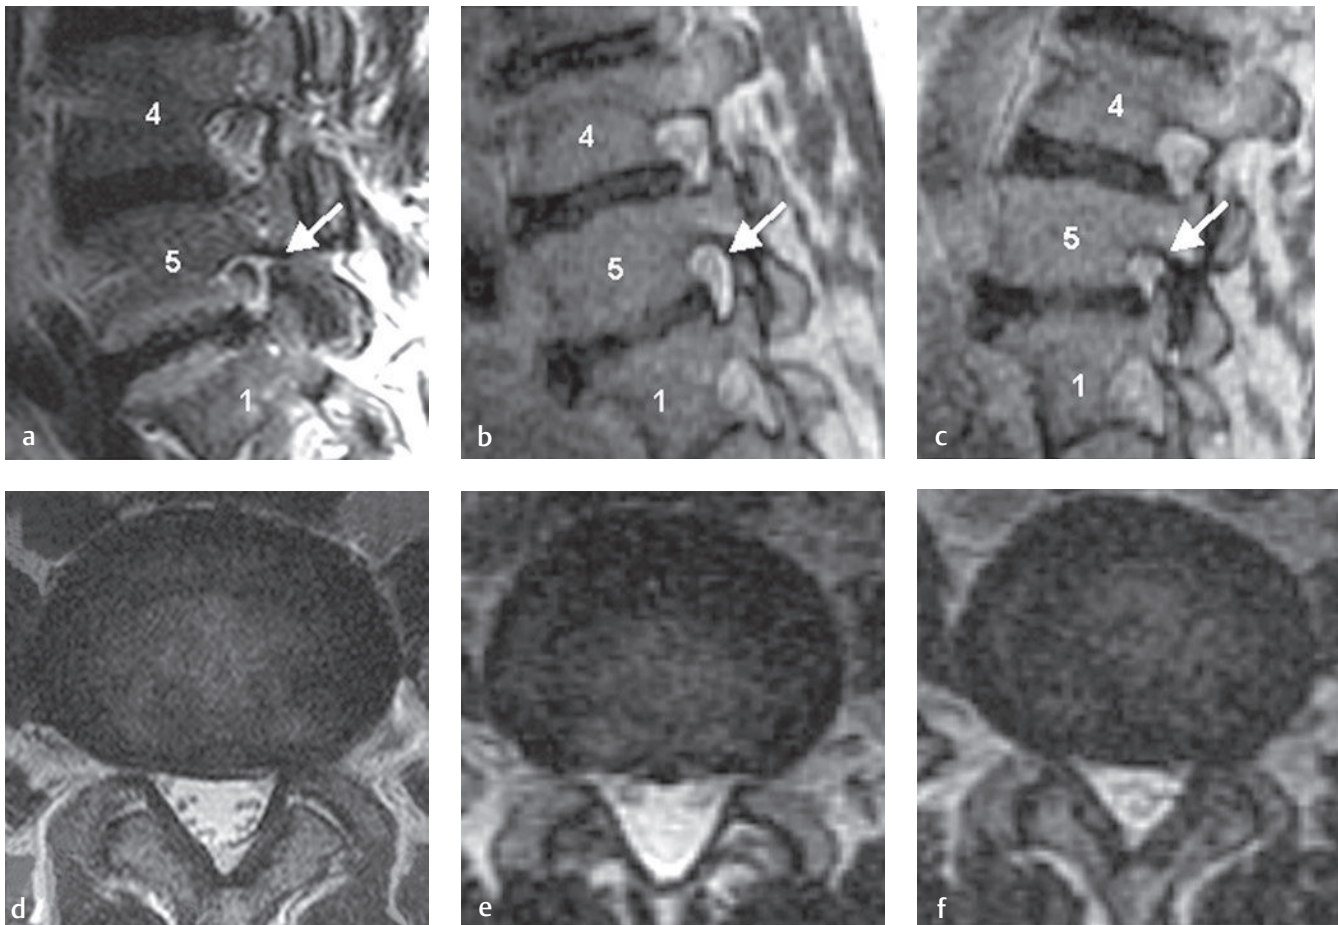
Load-bearing spine imaging: seated positional paradigm. These (a–c) sagittal and (d–f) axial T2-weighted images were obtained in a specially designed vertically open 0.5-T MRI scanner (General Electric Medical Systems). The patient was seated and images were acquired in (a, d) neutral, (b, e) flexion, and (c, f) extension positions. (a) The L5-S1 foramen shows a slight foraminal stenosis with deformity of the epidural fat (*arrow*) on the conventional image. (b) This image obtained with the patient in seated flexion shows improvement, with increased epidural fat surrounding the exiting nerve (*arrow*). (c) This image obtained with the patient in seated extension shows a marked foraminal stenosis at the L5-S1 foramen, with epidural fat only partially surrounding the nerve root present (*arrow*). The cross-sectional area of the dural sac increased from (d) 150 mm² in the supine position to (e) 170 mm² in upright (seated) flexion and (f) decreased to 110 mm² in upright (seated) extension. These images reveal that spinal canal and neural canal dimensions are position dependent.[†] (Courtesy of Dominik Weishaupt, MD, Institute of Diagnostic Radiology, University Hospital, Zurich, Switzerland.)
